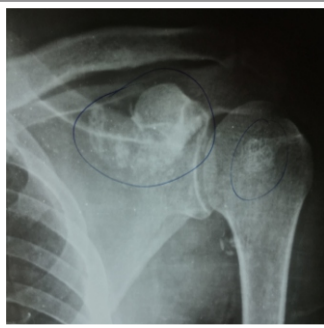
Radiographs at presentation
